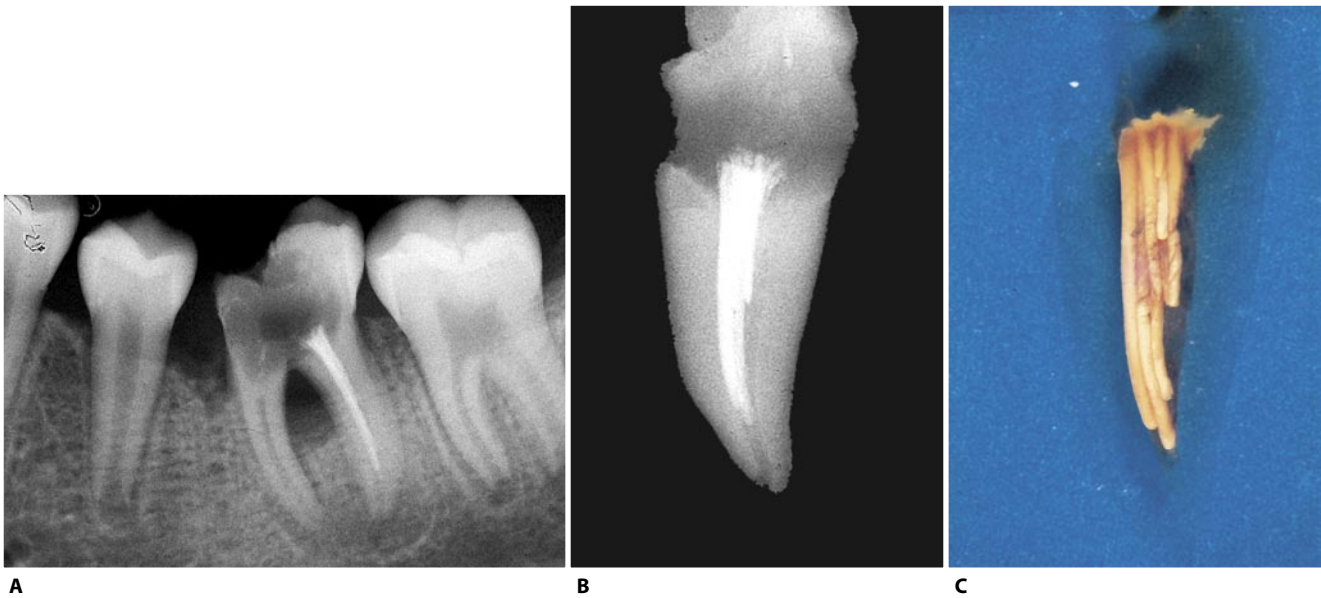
A poor example of “lateral flanking” of several gutta-percha cones, without any sign of “condensation.” A. Preoperative radiograph of the lower left first molar. Extraction was elected. B. The distal root in a mesiodistal view. C. The same root after decalcification and clearing.
